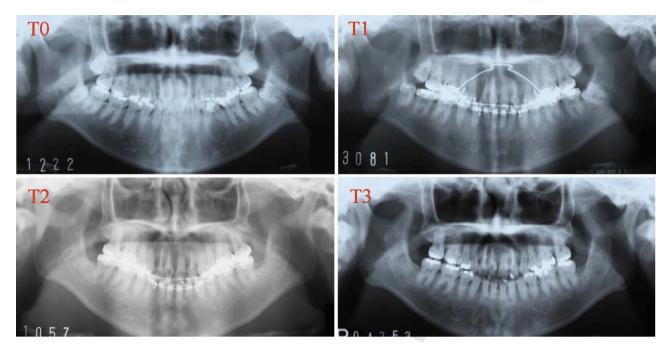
Panoramic radiographs (Case 1). T0: initial examination; T1: before maxillary anterior retraction; T2: after maxillary anterior retraction; T3: during retention.
